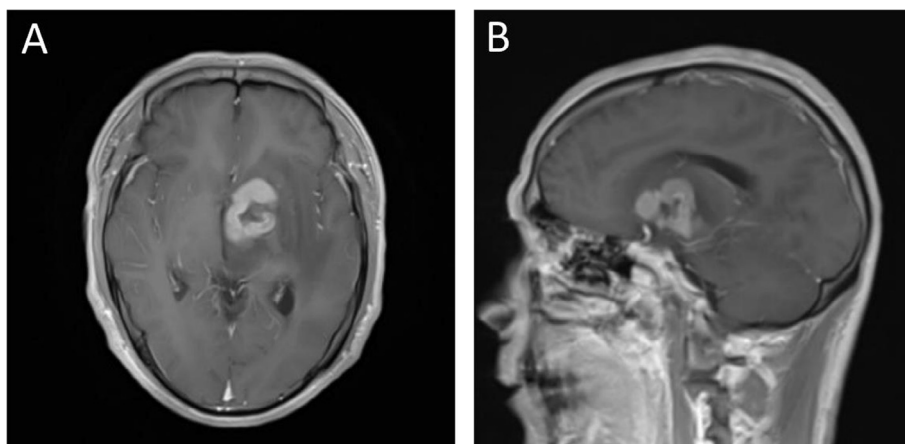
Case 2: Enhanced MRI of primary central nervous system lymphoma With enhanced MRI scanning, the lesion was shown gyriform enhancement, the enhanced region showed gap-shaped lesion while no enhanced region showed snow mass-shaped change; no enhancement was found in edema area around tumor, left lateral ventricular and suprasellar cistern and aqueduct of midbrain were deformed under pressure, and the central line structure moved to right. A: Axial view; B: Sagittal view.
